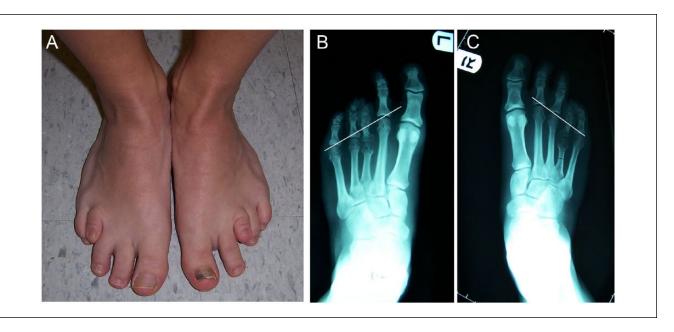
Preoperative clinical photograph and radiographs (A) Clinical photographic image of the patient's feet showing the congenital brachymetatarsia of the left third and right fourth metatarsals. (B,C) Standing frontal radiographs of both feet demonstrating shortening of the left third metatarsal by 18 mm (40.9%) and the right fourth metatarsal by 12 mm (27.3%) calculated by measuring the distance from the short metatarsal head to the line defining the metatarsal head parabola (white line) extending from the second to the fifth MTP joints.
